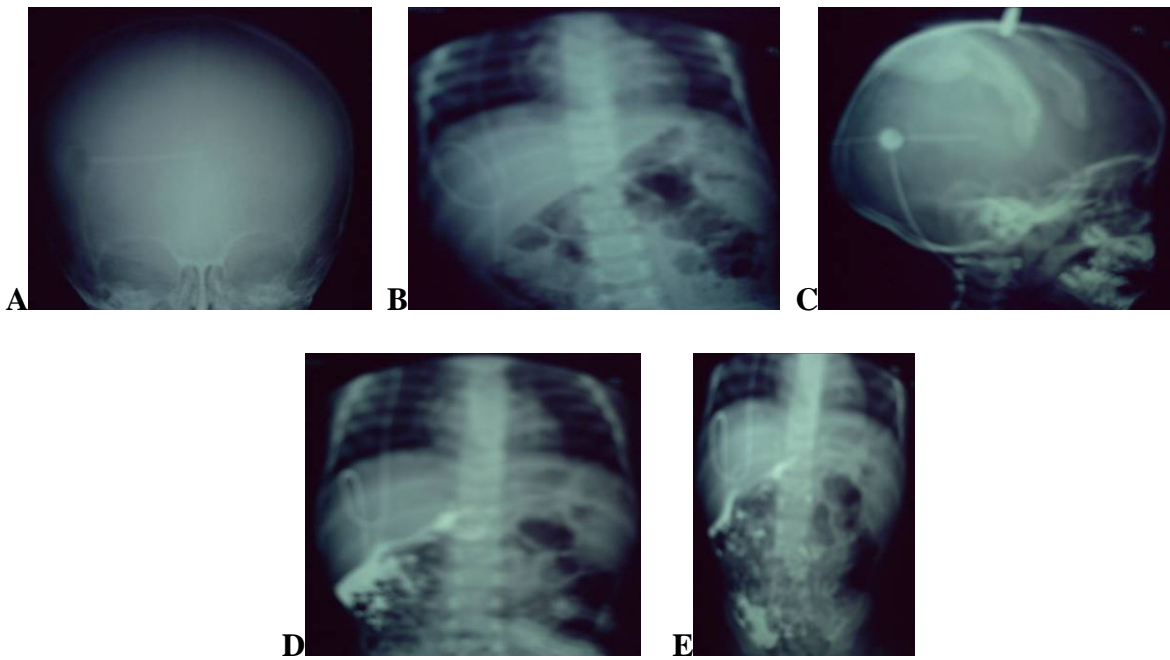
Case 10: male patient 2 years old, radiographic shuntogram was normal as evidenced by easy aspiration of CSF and free peritoneal spilling of contrast
